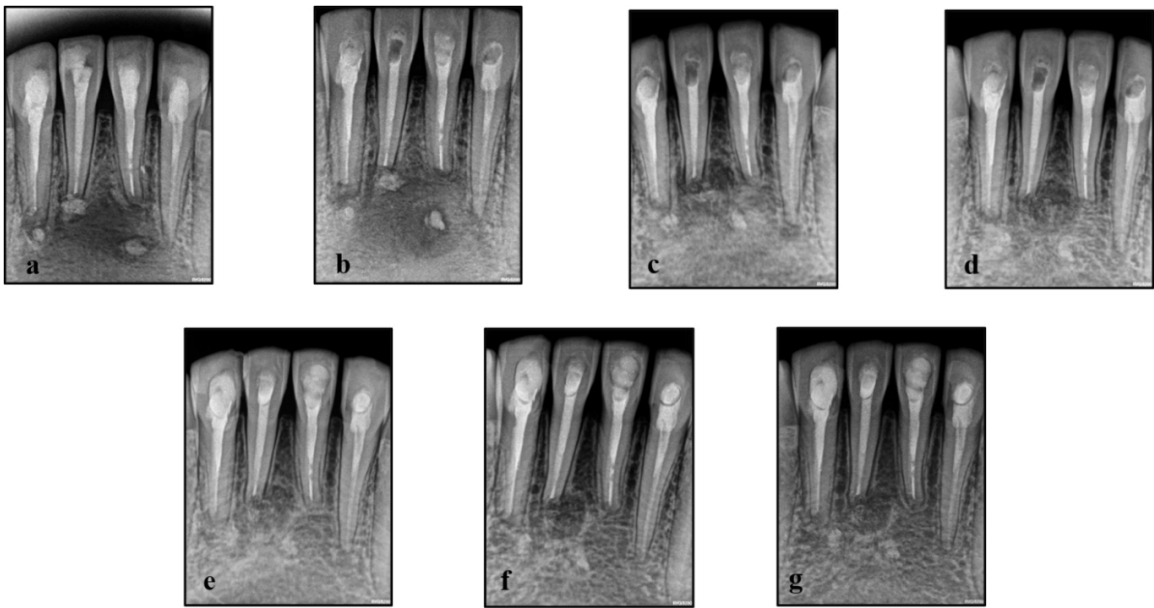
Periodic radiographic follow up, A: 1 week, B: 1 month, C: 3 months, D: 6 months, E: 9 months, F: 12 months, G: 15 months
